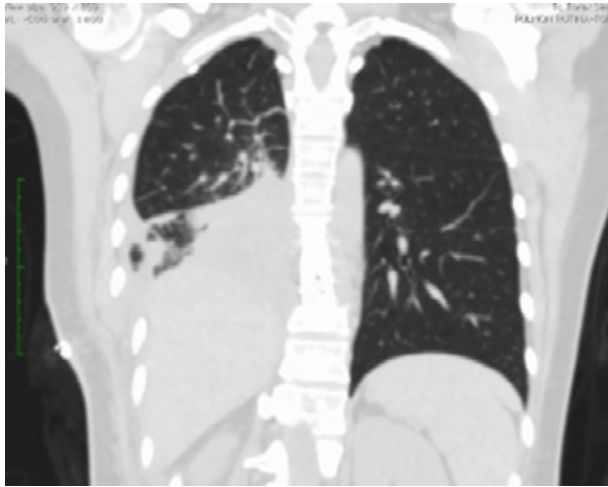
Control CT scan that shows lung parenchyma window 10 days after surgery.
